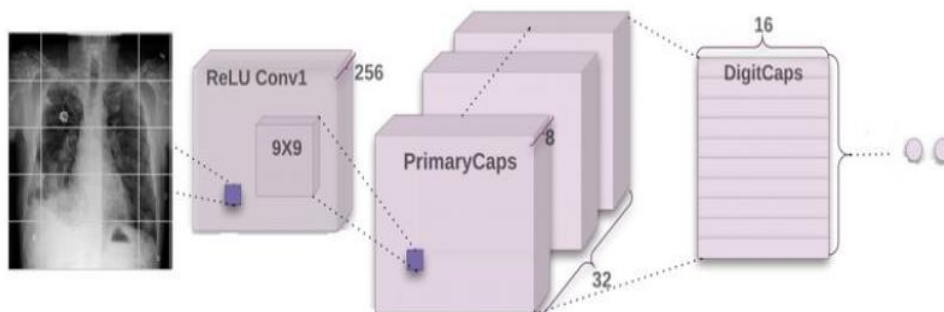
Network for Lung X-Ray Images Prediction.
